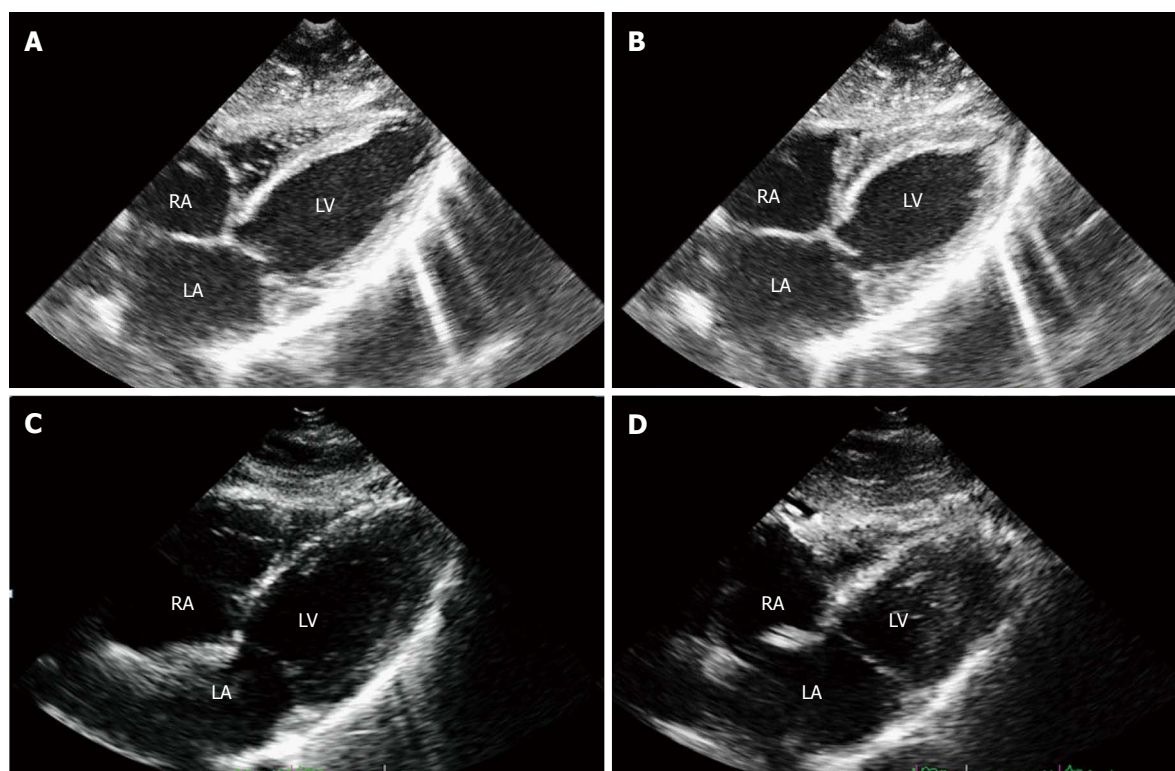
Two-dimensional echocardiogram, subcostal four chambers view, showing the anteroseptal and posterolateral walls of the left ventricle. End-diastolic (A) and mid-systolic (B) frames at the time of acute cardiac symptoms presentation showed dyskinesia of basal and medium segments, with hyperkinesia of the left ventricular apex. One week later, recovery of the wall motion abnormalities was demonstrated, with hyperdynamic ejection fraction (C and D). A previous echocardiogram performed two years before in this patient was similar to this last one. RA: Right atrium; LA: Left atrium; LV: Left ventricle.
